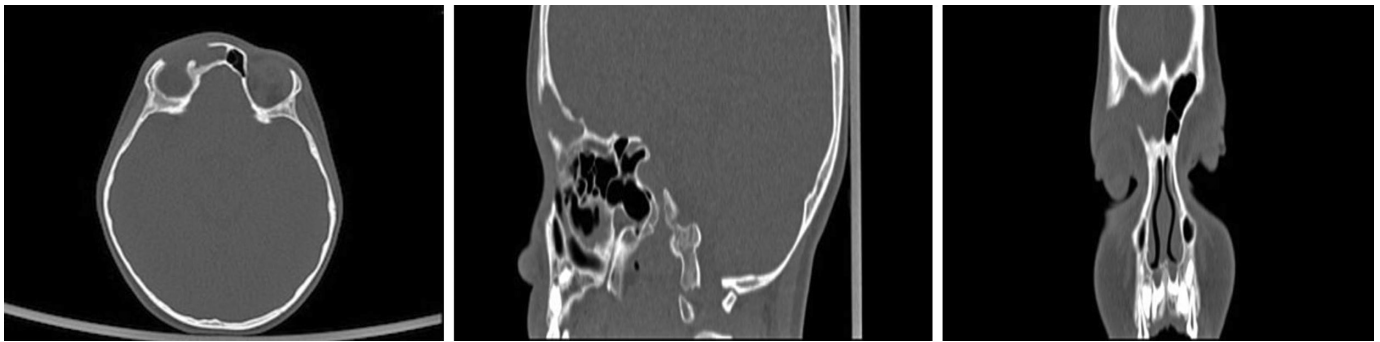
CT images in axial, coronal, and sagittal sections.
